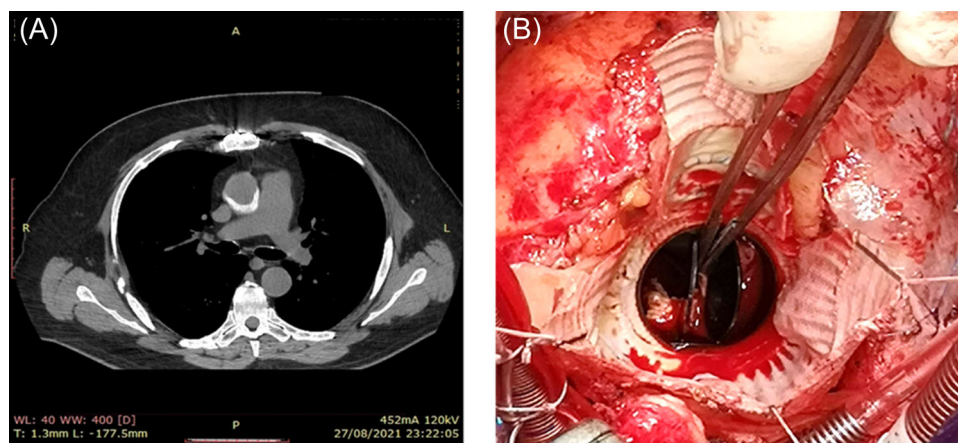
(A) Computed tomography scan showed vegetations in the lumen of the aortic graft. (B) Intraoperative view of yellowish and friable vegetations located to the annulus of the mechanical valve.
